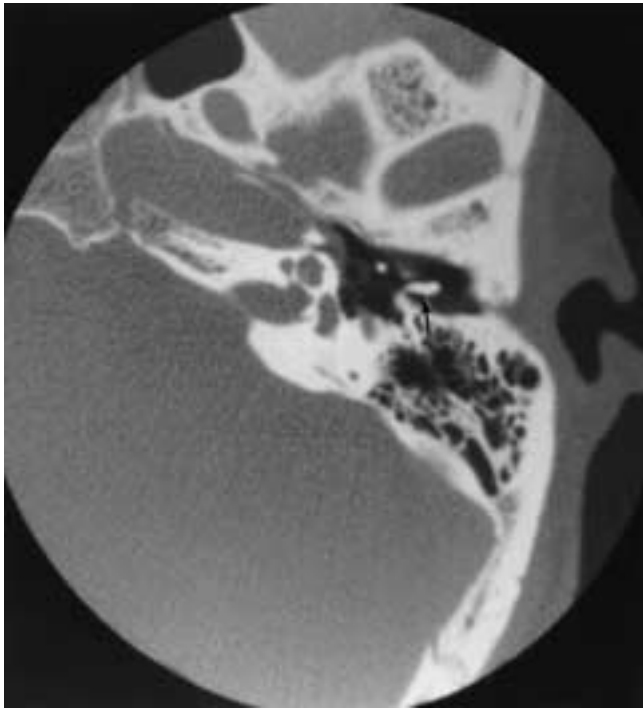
Incus dislocation. Magnified axial CT image, left ear. The incus (*arrow*) is dislocated into the external auditory canal. (Courtesy of Dr. F. Veillon)
